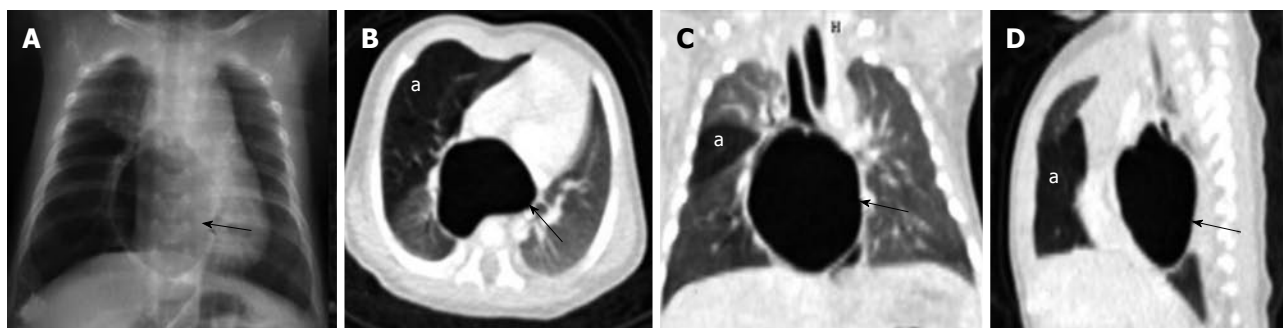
Bronchogenic cyst. Frontal radiograph of chest (A) shows a well-defined air filled cystic lesion in the retrocardiac location. Axial (B), coronal (C) and sagittal (D) MPR images show a large well defined homogenous air containing lesion (arrow) with carinal widening. The lesion is causing partial airway obstruction seen as air trapping in right middle lobe (a). MPR: Multiplanar reformation.
